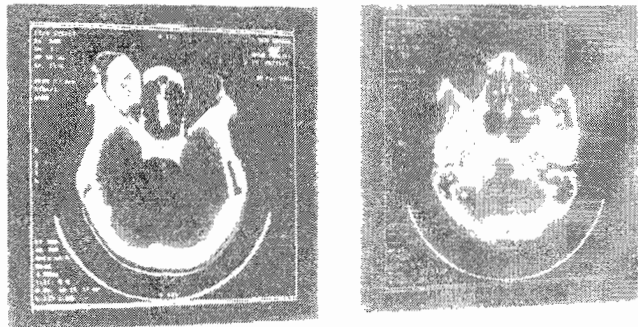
Computed tomography of the head, sinuses and orbit showing a right retrobulbar contrast enhancing soft tissue mass attached to the optic nerve and displacing the eyeball antero-laterally.
